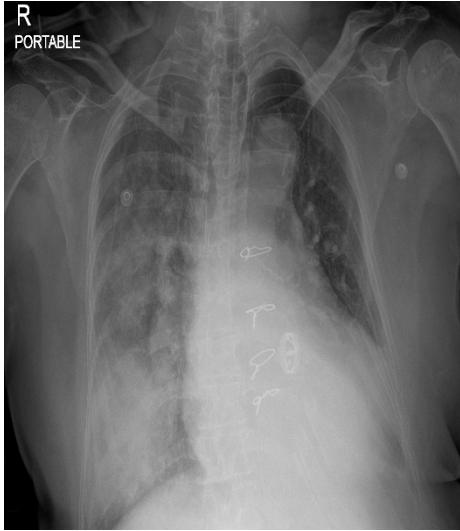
Chest X-ray on day 4 and day 11 which shows infiltrates in the right lung, left lower lobe collapse, cardiomegaly and left lobe collapse consolidation, cardiomegaly respectively.
